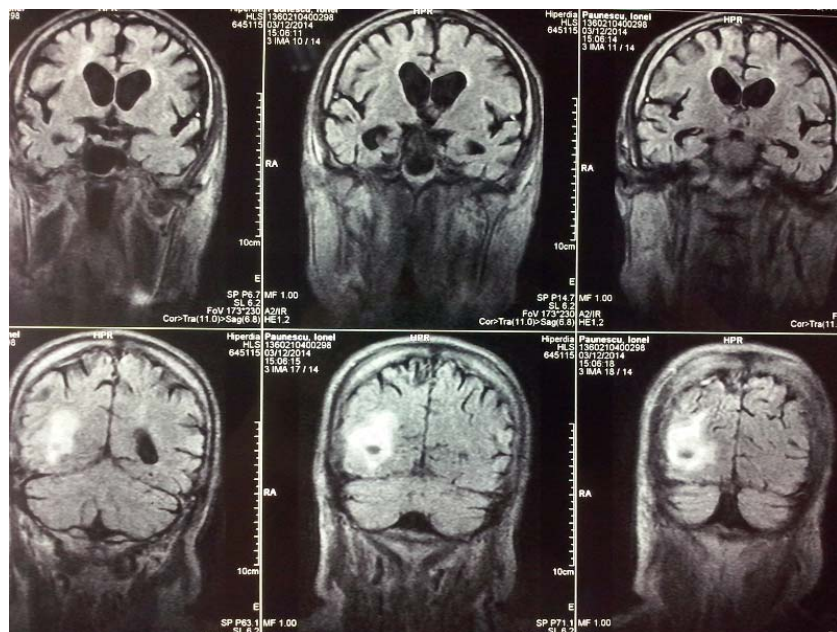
Cerebral IRM (FLAIR)-Subacute right parietal hemorrhage, old cerebral infarction in the right anterior cerebral artery area, old lacunar infarcts and cerebral atrophy.
